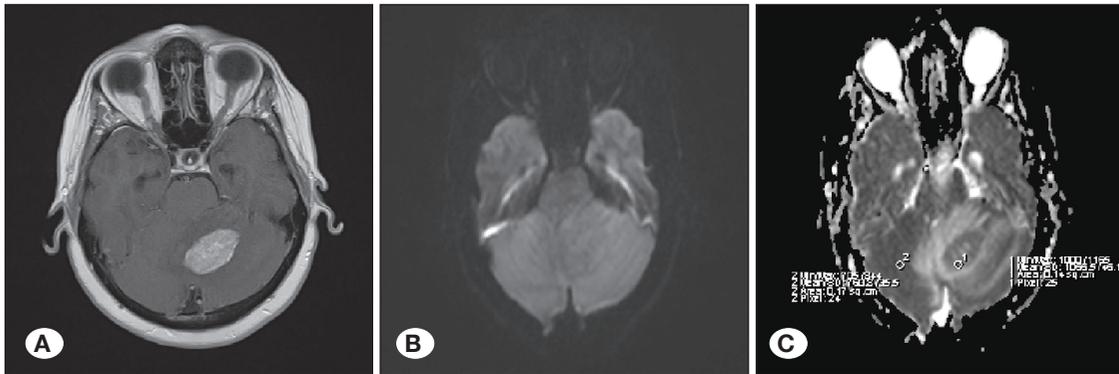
Representative MR images in which the ROI within a tumour and the related contralateral normal-appearing white matter are presented for computing apparent diffusion coefficient values for the brain metastases. Contrast enhancement of the left cerebellar metastasis in patients with breast carcinoma is demonstrated on contrast-enhanced T1 weighted images (1). Negative findings are seen on diffusion-weighted imaging (DWI) (B). ADC map with ROIs inside the tumour and the relevant contralateral normal-appearing white matter (C).
